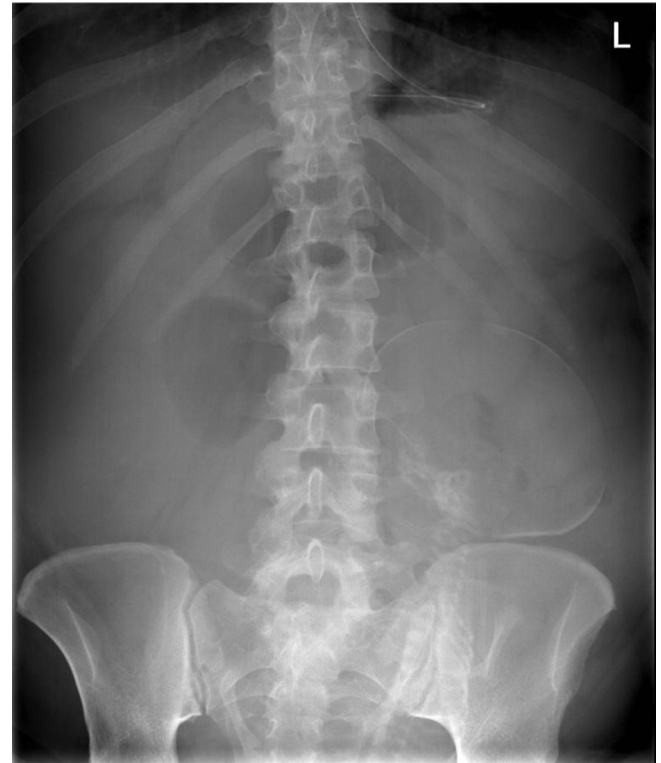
Plain abdominal radiographic image showing a distended transverse colon.
